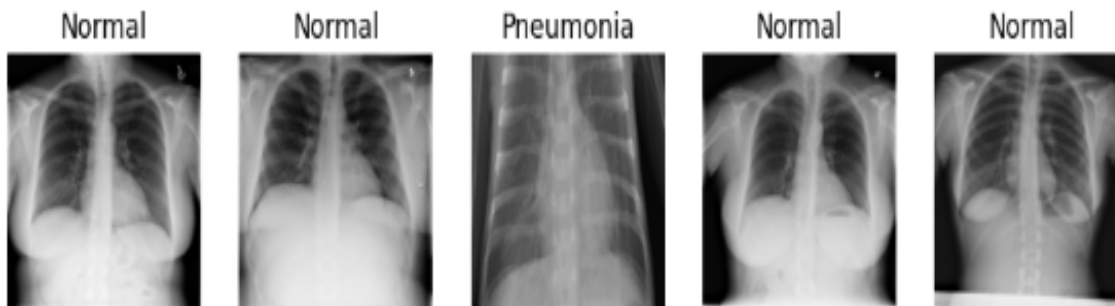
Chest X-ray Dataset Sample
